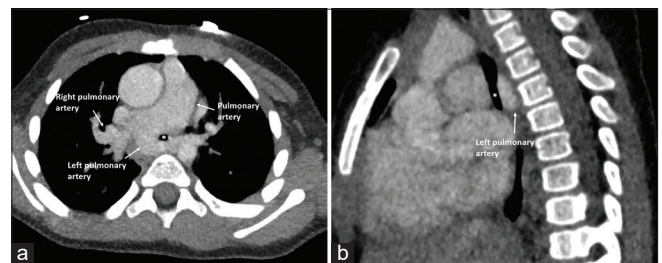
Multislice computed tomography showing the course of the left pulmonary artery (a) and the luminal narrowing of the distal trachea (*, a and b)
